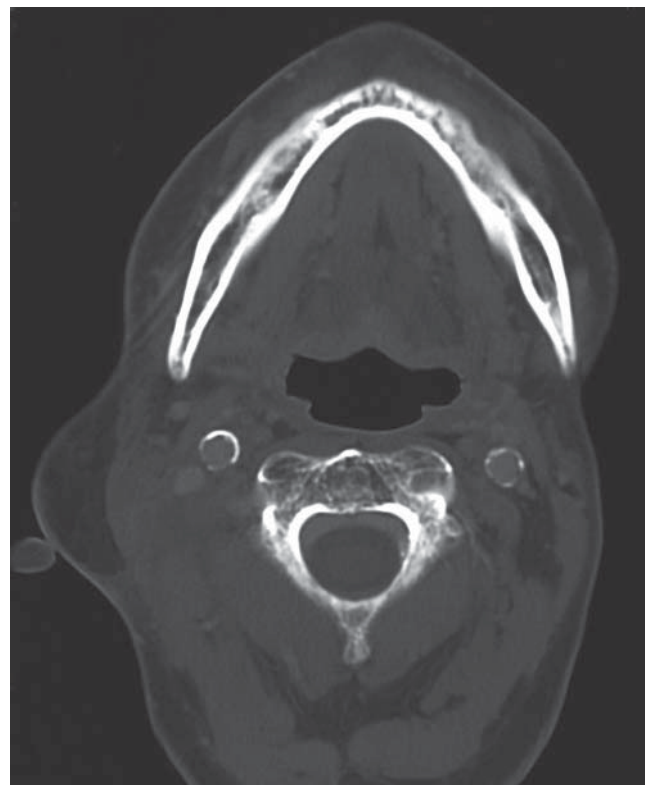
CT scan showing complete remission of the tumor with post-radiotherapeutic alterations in the flap tissue and marked atherosclerotic lesions in the carotid arteries.
